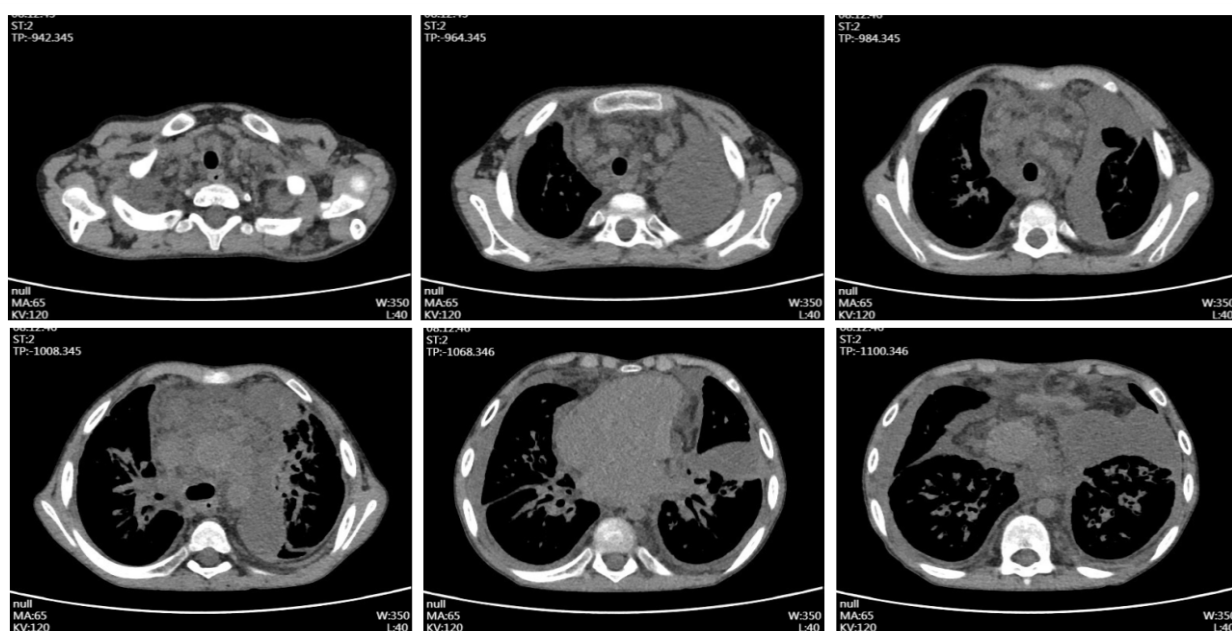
Cross-sectional scan of the patient's chest CT.
